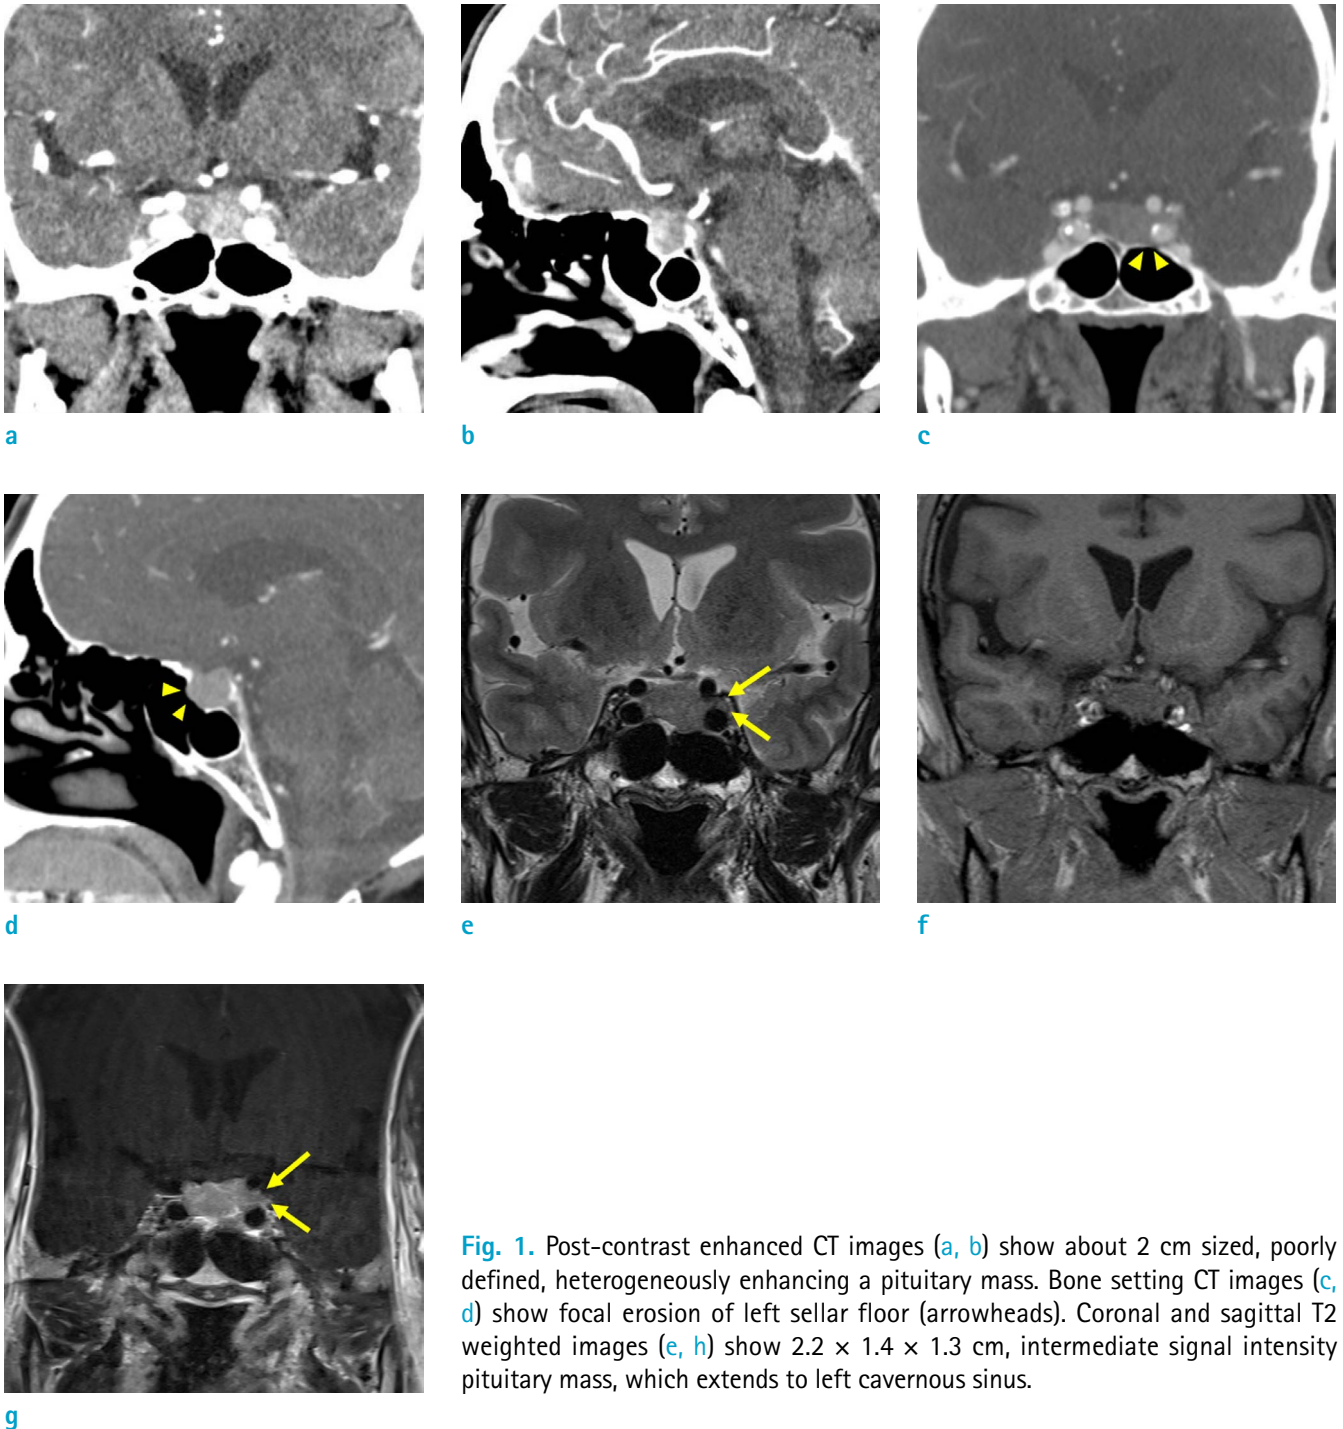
Post-contrast enhanced CT images (a, b) show about 2 cm sized, poorly defined, heterogeneously enhancing a pituitary mass. Bone setting CT images (c, d) show focal erosion of left sellar floor (arrowheads). Coronal and sagittal T2 weighted images (e, h) show 2.2 × 1.4 × 1.3 cm, intermediate signal intensity pituitary mass, which extends to left cavernous sinus.
